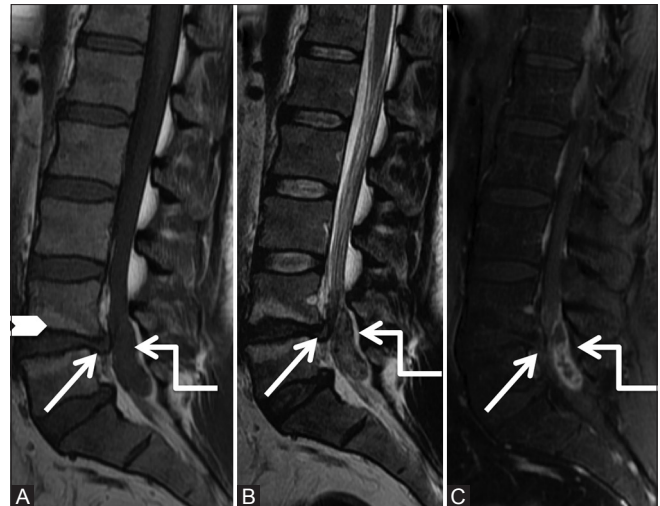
(A-C): Degenerative: Herniated disc: Sagittal T1-weighted (A), T2-weighted (B) and post-contrast T1-weighted fat saturated (C) images of lumbar spine showing posterior protrusion of L4-5 disc with posterior osteophyte (arrow) along with elongated posterior epidural soft tissue lesion (elbow arrow), which appears isointense on T1-weighted and heterogeneously hyperintense on T2-weighted and peripheral rim enhancement, causing severe canal stenosis. Note Type II fatty Modic degenerative changes at L4-5 end plates (arrowhead)
